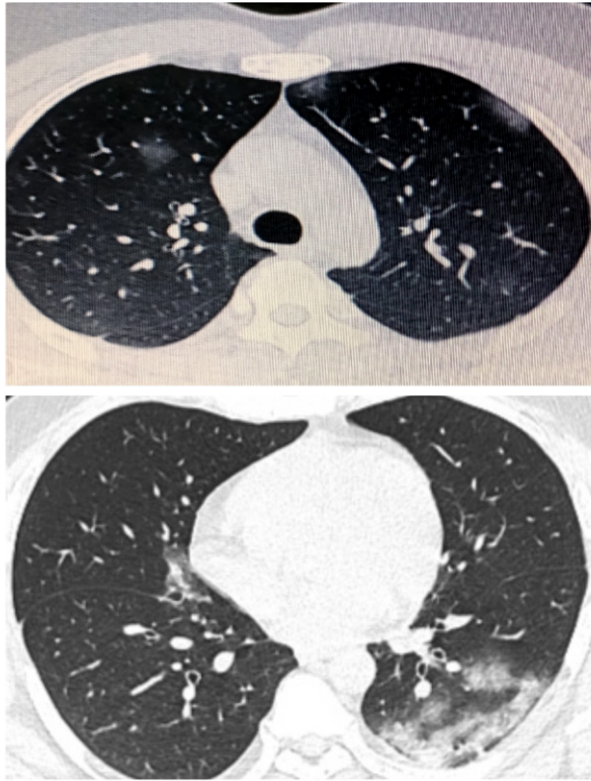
HRCT chest, axial section, lung window showing multifocal bilateral peripheral predominant rounded GGO with consolidation on the left lower lobe, consistent with CO-RADS 5.
